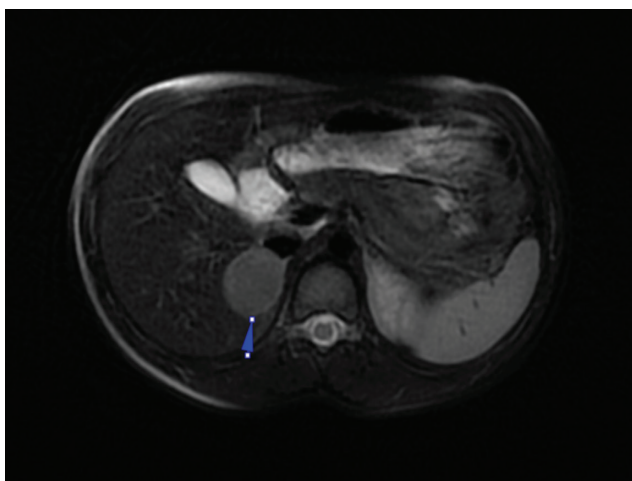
Abdominal MRI of the patient
